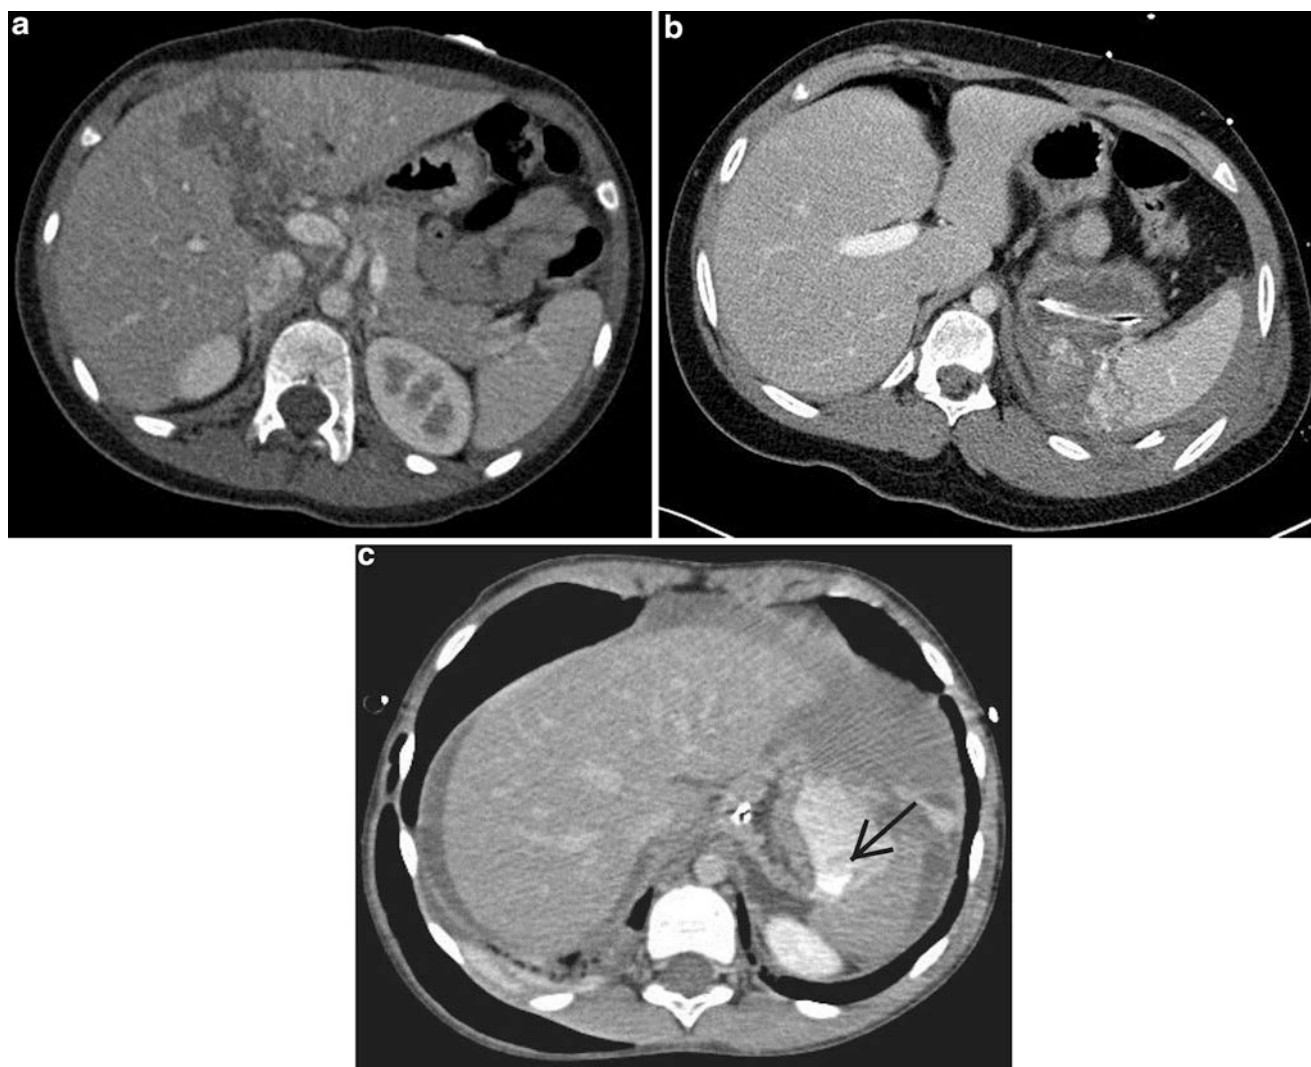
CT scan with intravenous contrast is the standard for evaluation of hemodynamically stable children with suspected solid organ injuries. (a) A 9-year-old girl who sustained a Grade IV liver laceration of the right hepatic lobe that extends into the porta hepatis; (b) Grade IV
